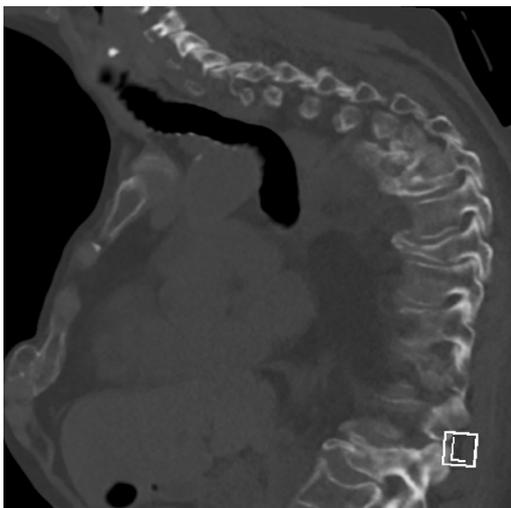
Sagittal view of computed tomography scan demonstrating severe kyphoscoliosis and tortuous trachea.
